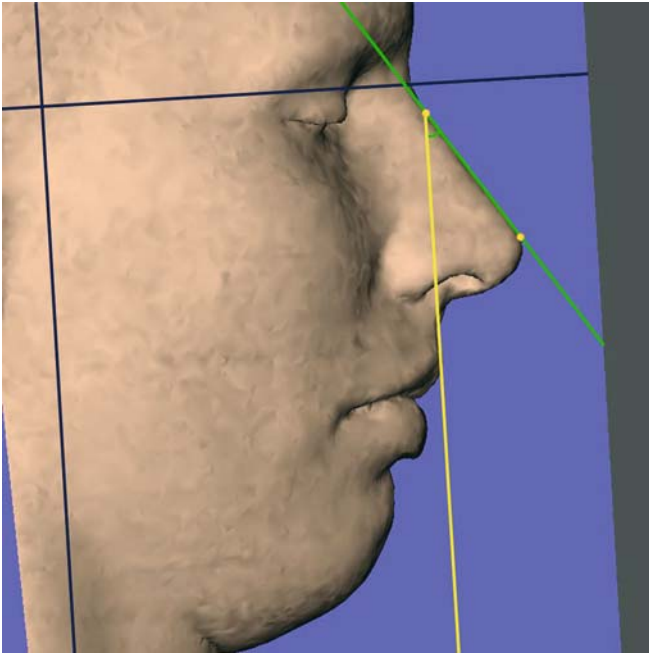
The inclination of the nasal bridge from the vertical plane, nasal root tangent / y -plane, is a projected angular soft tissue measurement on the median (z) 3-D cephalometric reference plane (3-D CT, soft tissues, patient K.C.)
